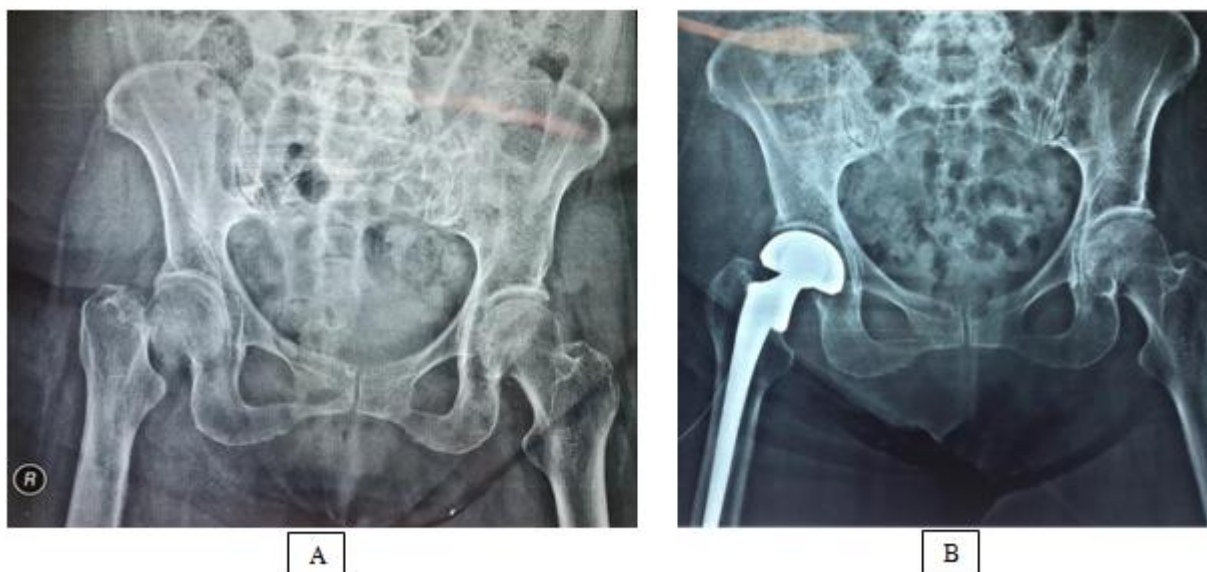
X-Ray Pelvis AP (A) Pre-Operative showing Closedright Column Femoral Fracture. (B) Post-Operative Cemented Hemiarthroplasty Bipolar Right Femur
